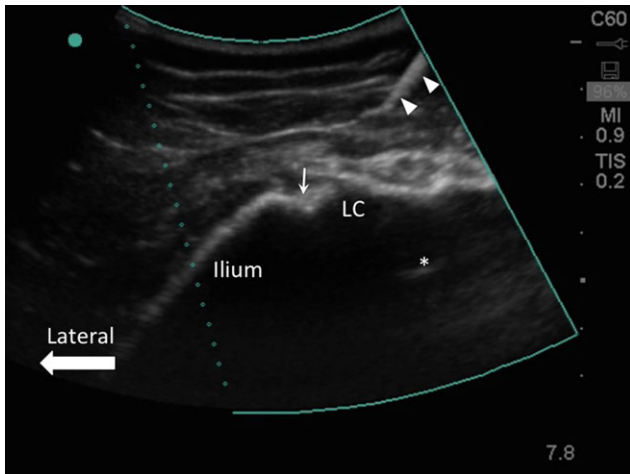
Ultrasound image of the lower part of sacroiliac joint. LC- lateral crest; bold arrow heads- needle; *- drop shadow of second sacral foramen; line arrow-sacroiliac joint. Reproduced with permission from Philip Peng Educational Series.
